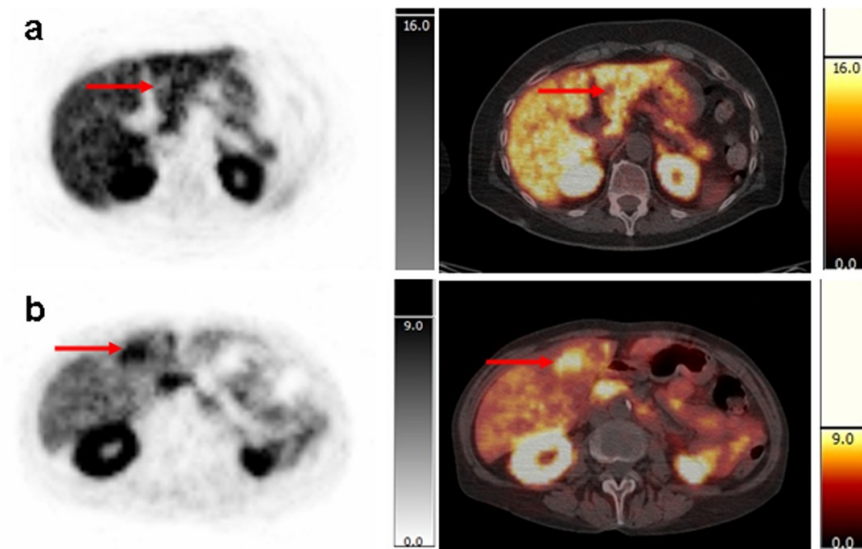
Axial slices of the PET and fused PET/CT showing uptake of $[^{18}\text{F}]\text{D4-FCH}$ in the liver metastases of two patients.
